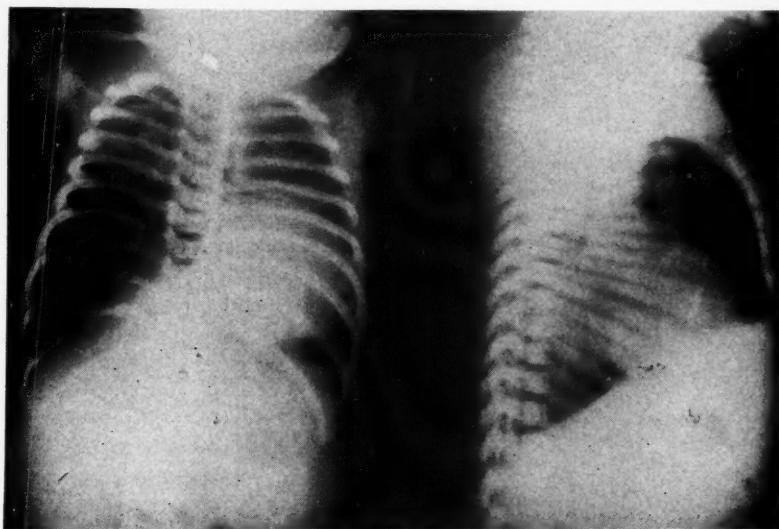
(Case 4) A seven-day-old female child who had marked respiratory distress and cyanosis from the third day. X-ray showed mid lung field emphysema and compression atelectasis of the right upper and lower lobes. Impression: hypertrophic lobar emphysema. (Surgery—lobectomy confirmed the diagnosis.)
